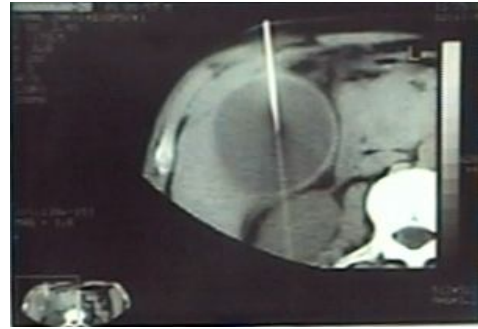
CT showing postoperative bile collection (note aspiration guided by CT).
